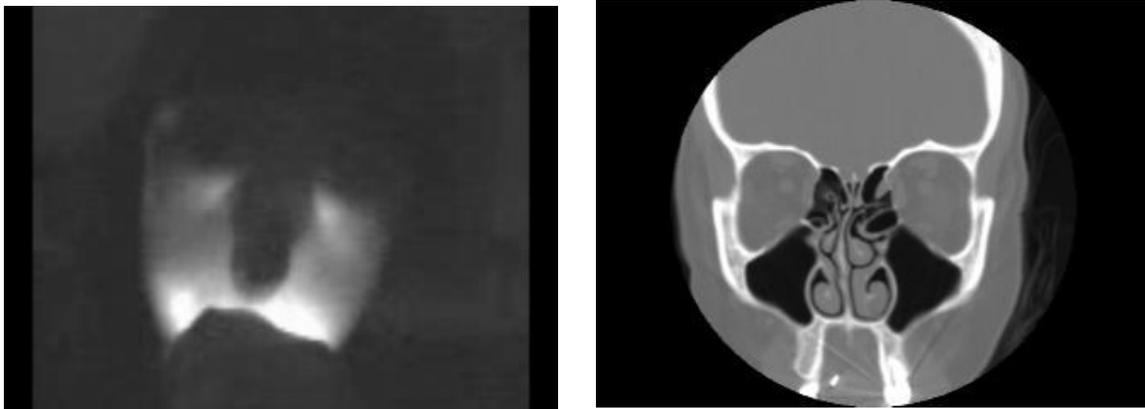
NIR transillumination pattern (left) of 33 year old Caucasian female with no history of nasal problems with corresponding CT scan (right) revealing bilaterally aerated maxillary sinuses. Note diffusely strong transillumination of mid-face structures with increased signal intensity along infraorbital rim.
